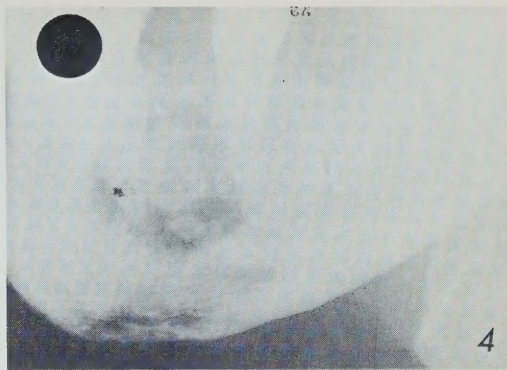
This periapical film shows loss of definition of the cancellous bone in the area of the extracted bicuspid.
